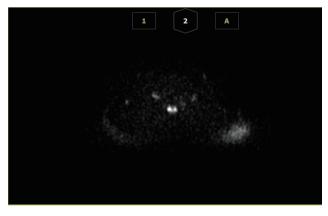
DWI revealed hyperintensity at the same level.
